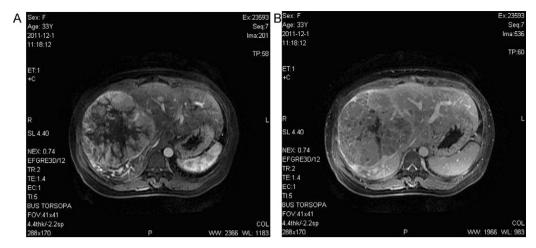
MRI showed a 15 cm × 15 cm × 14 cm HCC at the right liver with contrast enhancement in the arterial phase (Fig. 1a) and portal venous wash out in the venous phase (Fig. 1b).
